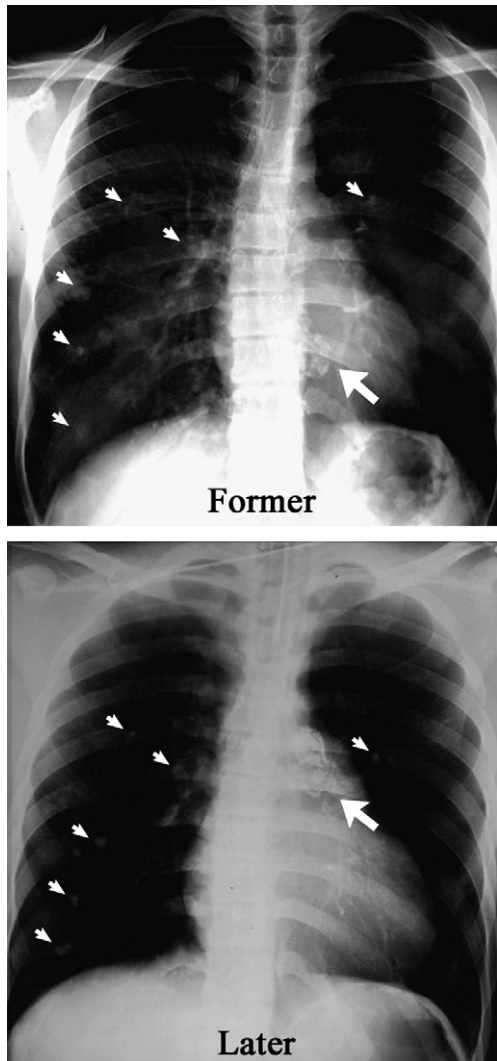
Chest X-rays. *Former*: A large tumor in the right heart (large arrow) appears along with several pulmonary nodules in the bilateral lung field, especially in the right lung field (small arrows) taken at 4 days before admission. *Later*: A large fragment of the tumor moves to pulmonary trunk (large arrow) causing pulmonary embolism taken right after the crisis.
